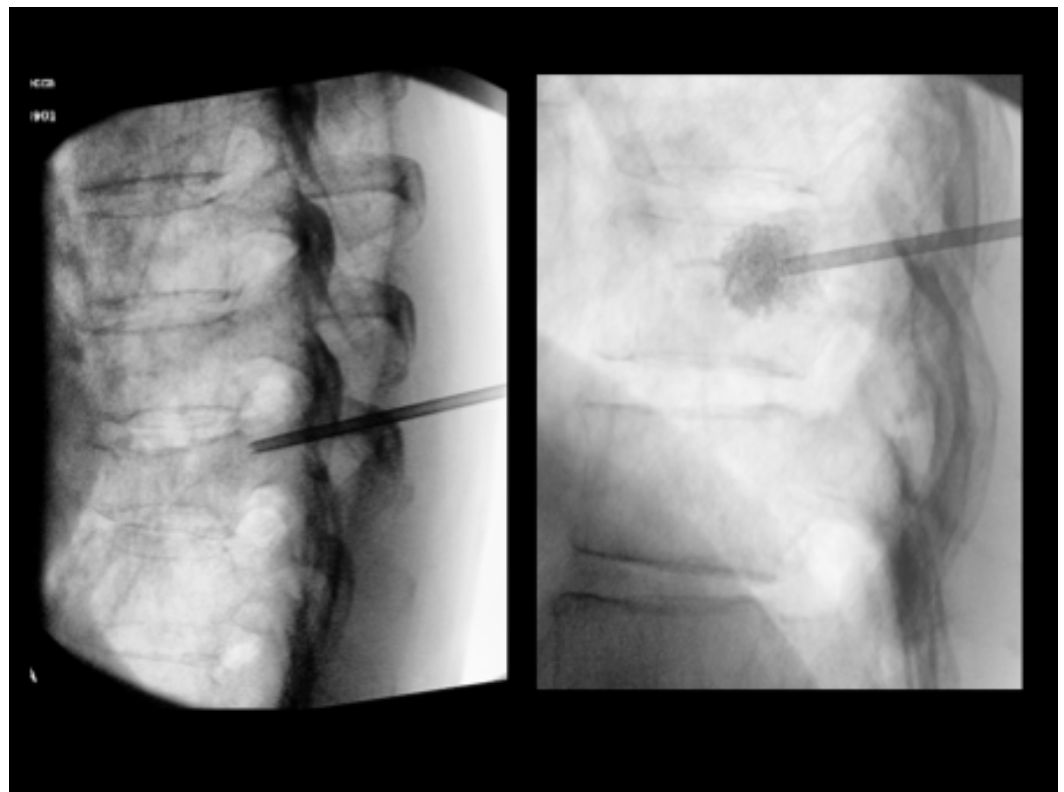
Fluoroscopic imaging of vertebral augmentation. Under sedation or general anaesthetic, a cannulated needle is passed into the vertebral body through the pedicle. In kyphoplasty an inflatable balloon is inserted that corrects some of the deformity. The void is then filled with cement. In vertebroplasty no attempt is made to correct and cemented is injected into the acute fracture. These are anonymised procedural X-rays from a patient, with consent for their use.
